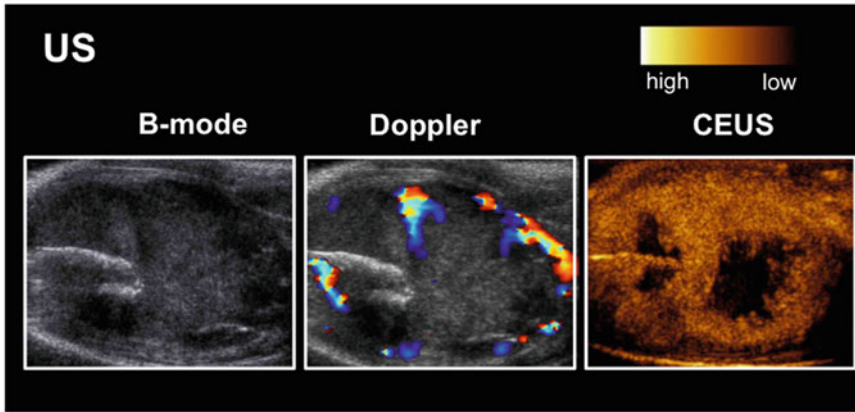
US images from B-mode (morphology, *left panel*), Doppler (perfusion, *middle panel*), and contrast-enhanced US (CEUS; *right panel*, peak enhancement after injection of microbubbles from real-time imaging of vascularization) of a bone metastasis. Figure reprinted with permission from [14]
